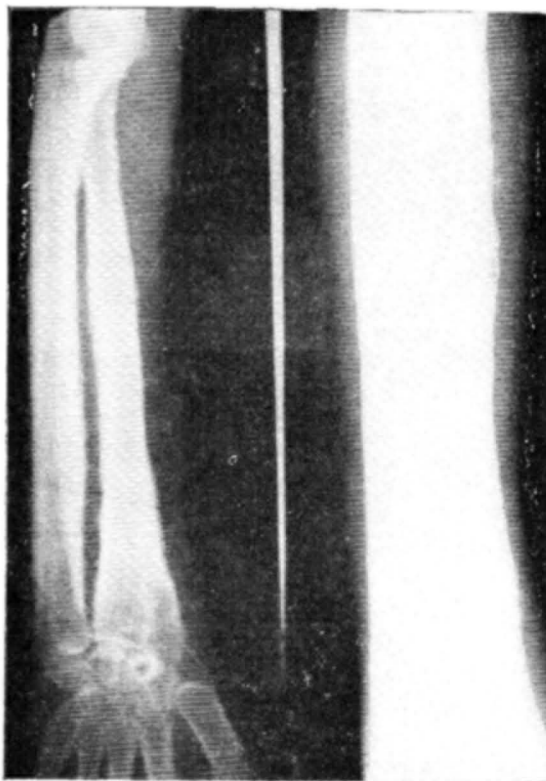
X-ray of forearm and leg - periosteal reaction along the medial length of radius in lower 2/3rds. Corte is thickened in both ulna and radius in lower 2/3rds. X-ray leg shows periostitis in tibia of the lower 2/3rds. Cortex thickened along the whole length of the lower half.
